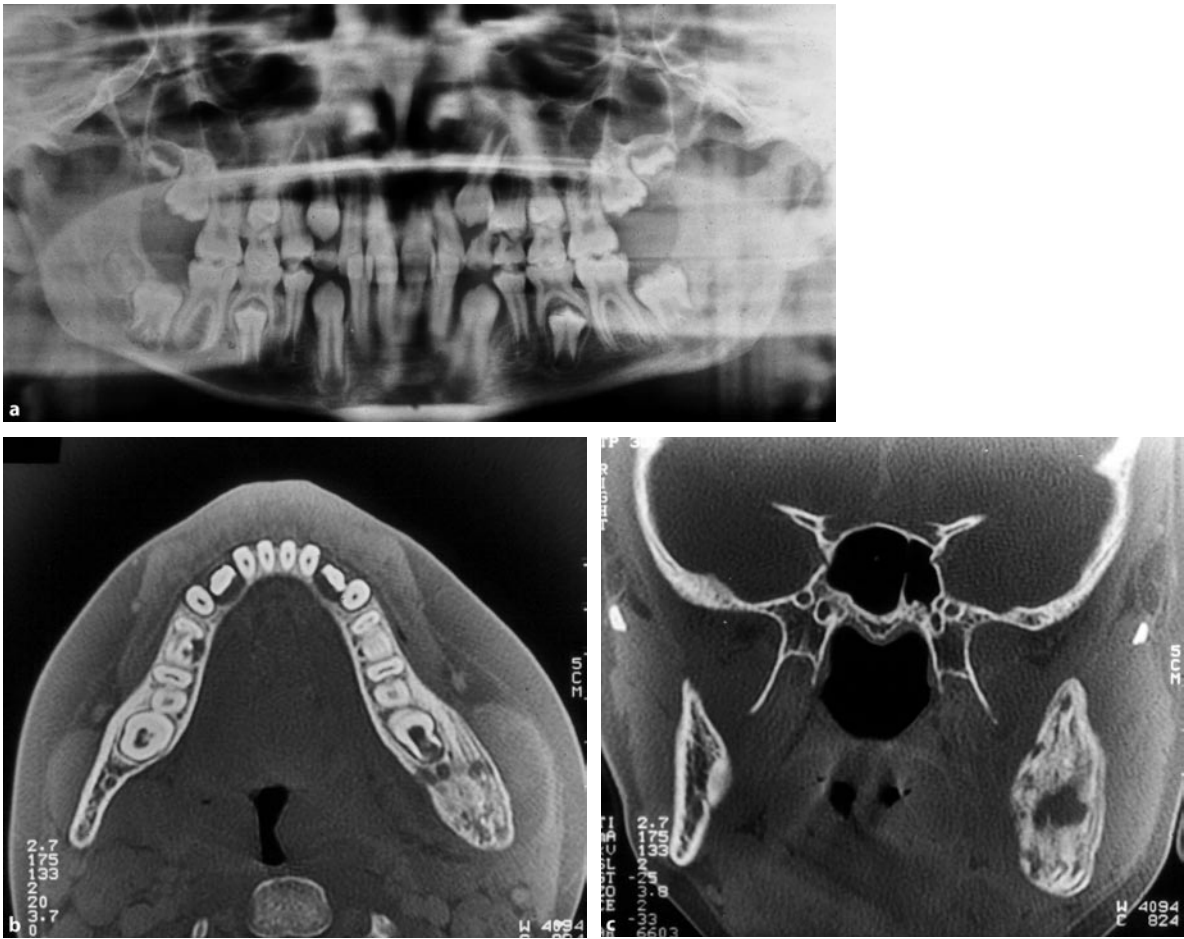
A 12-year-old boy with early-onset primary chronic osteomyelitis of the left mandible: note the onion-like pattern of the periosteal reaction (ossifying periostitis), which is seen in the OPG (a) and more clearly demonstrated in the axial and coronal CT scans (b,c). The
